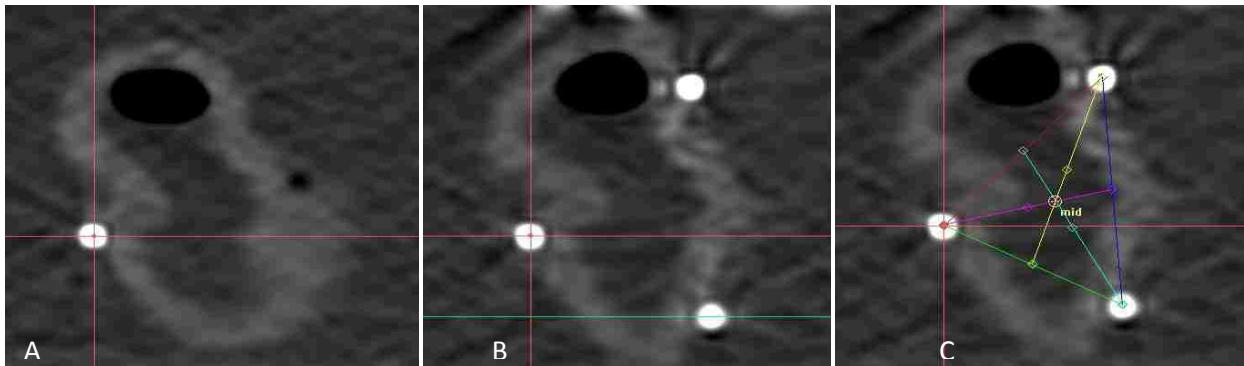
Method for determining the centroid of each set of fiducial markers. (A) Find a CT slice with one of the markers and center the ECS coordinate system in that point. (B) Manipulate the ECS coordinate system until the centers of all points are visible in the same slice. (C) Draw the medians of the triangle. The point where the three medians intersect is the centroid.
